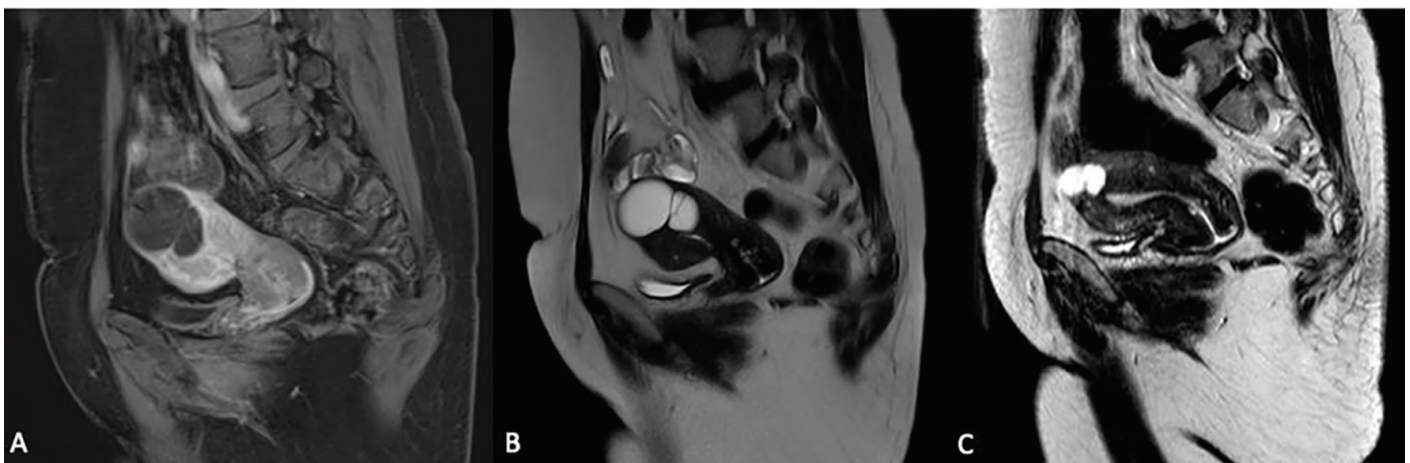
A mesothelial cyst with smooth borders that appears hypointense on T1-weighted MRI (A), and hyperintense on T2-weighted MRI (B). The patient's MRI image taken 5 years ago (C)
